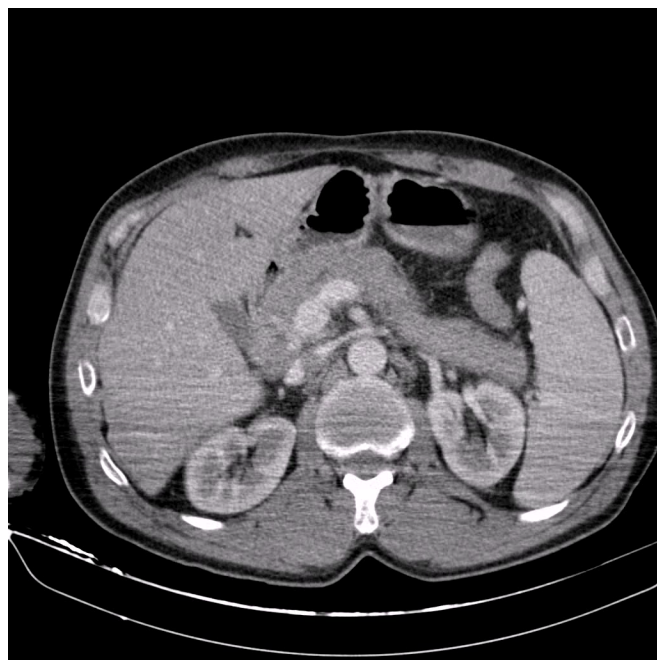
Initial CT scan compatible with acute pancreatitis
